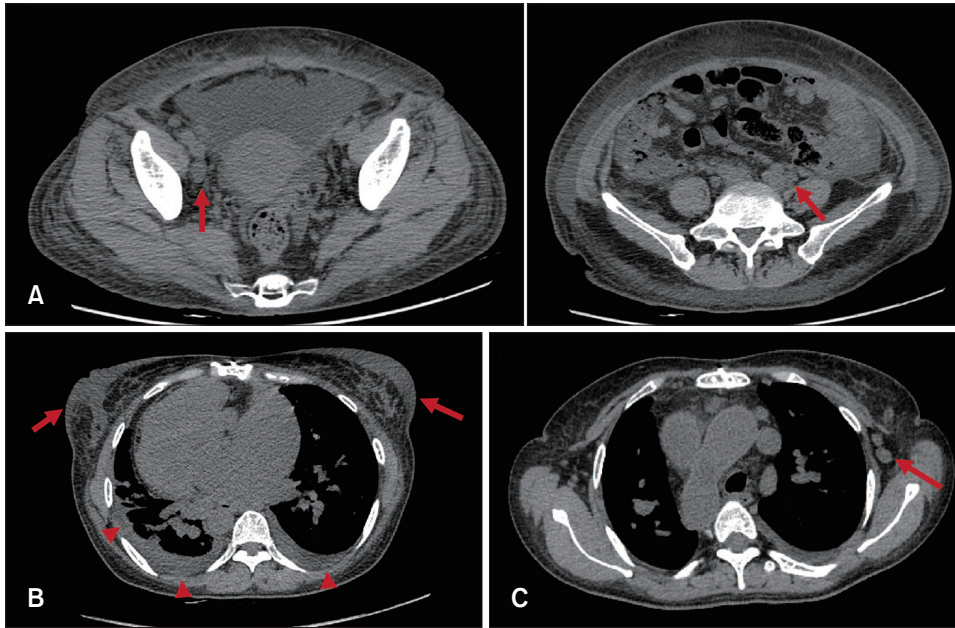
Lymphadenopathy and pulmonary involvement based on chest computed tomography. (A) Increased size of multiple lymph nodes (arrows) in the retroperitoneum, both iliac chains, and inguinal area. (B) Diffuse body wall edema and skin thickening of both breasts (arrows) with pulmonary edema and bilateral pleural effusion (arrowheads). (C) Multiple enlarged lymph nodes (arrow) in the axillae.
